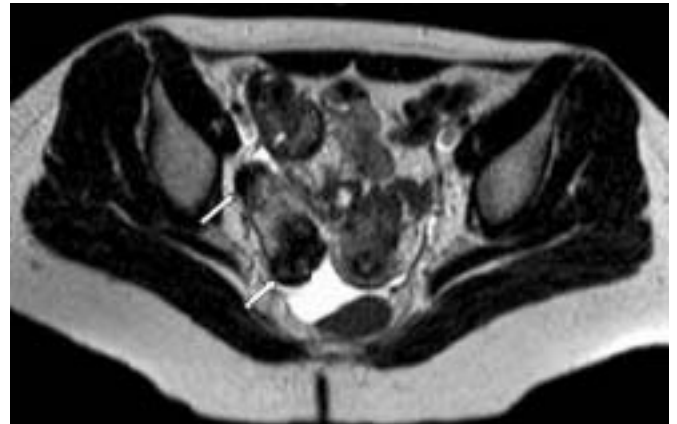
Axial T2-weighted MR image shows two ovarian well defined lesions (arrows; anterior 18x18 mm, posterior 34x25 mm) with very low signal intensity, a finding that is suggestive of an ovarian fibroma
